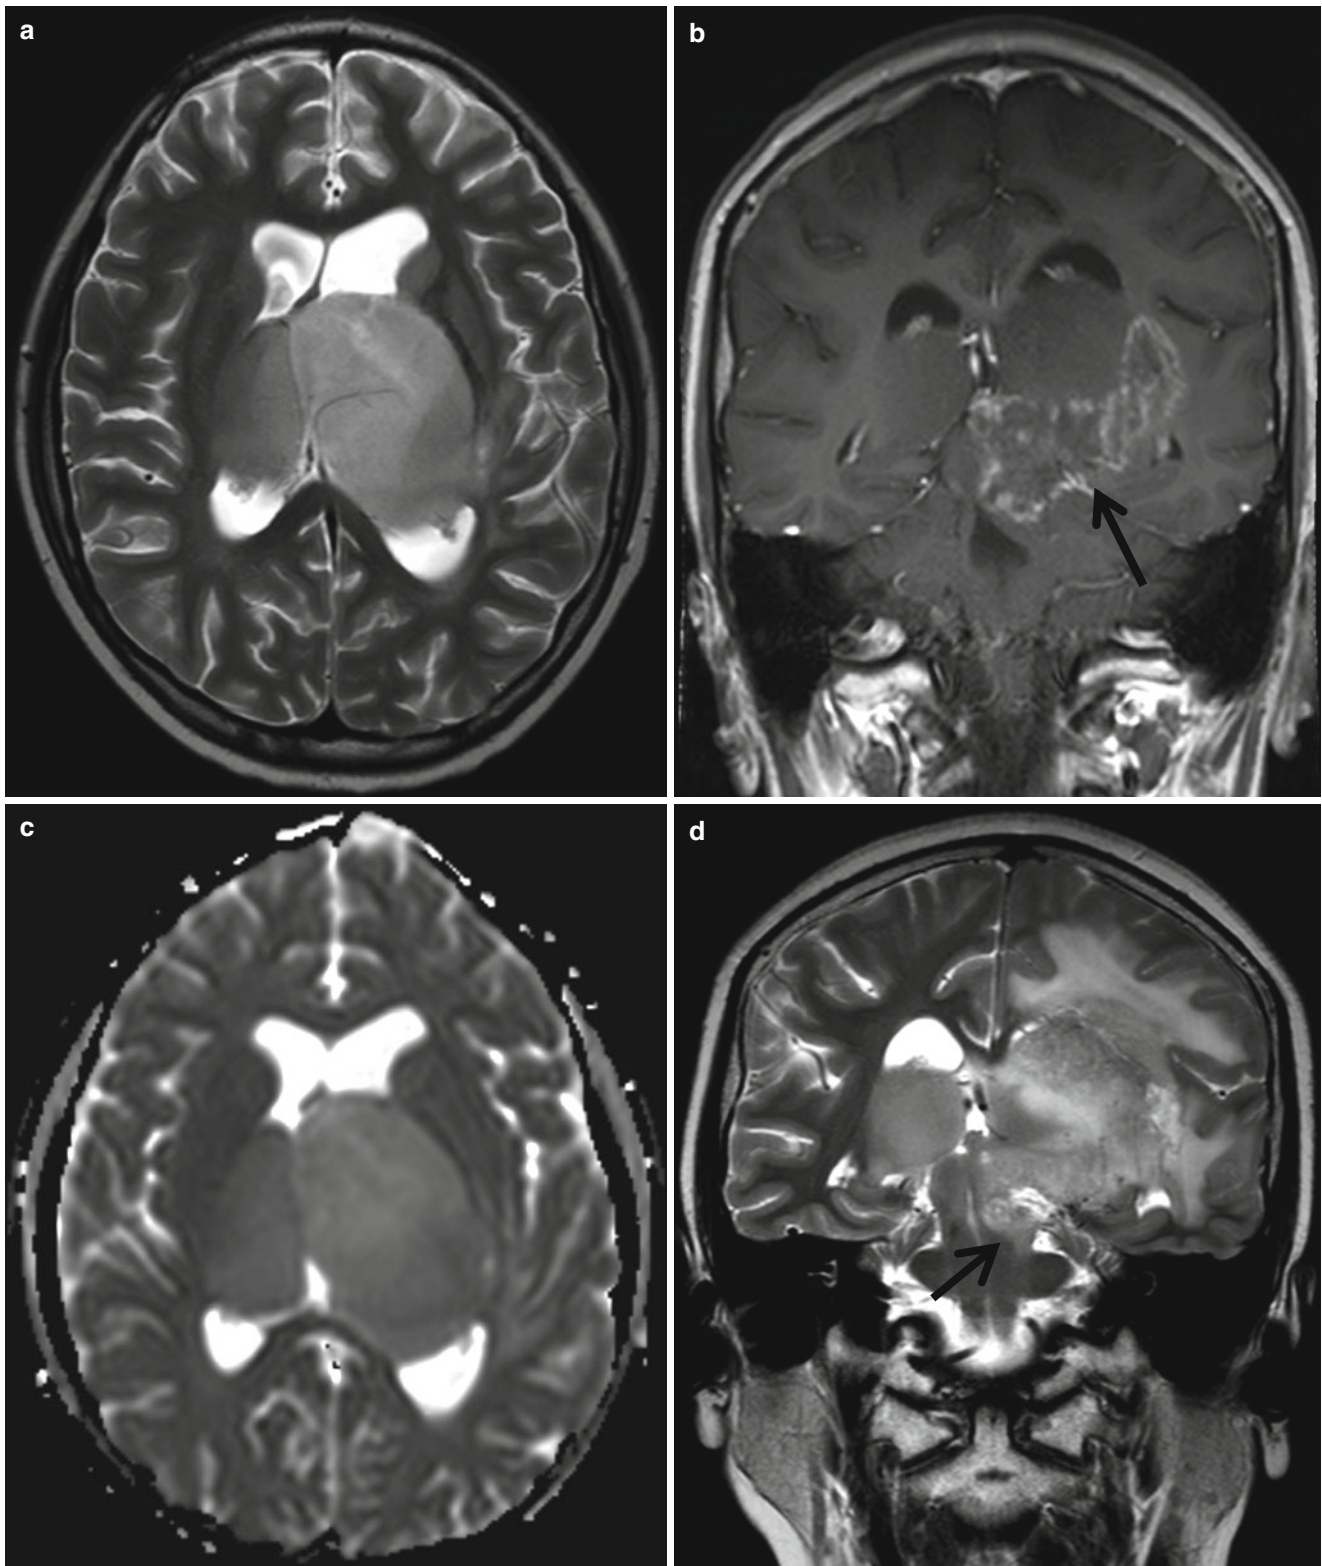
Anaplastic astrocytoma involving bilateral thalami. (a) Bilateral thalamic mass causing enlarged thalami are seen on T2-weighted image. (b) Focal heterogeneous enhancement (arrow) is noted on postcontrast coronal image. (c) The mass exhibits iso-signal
